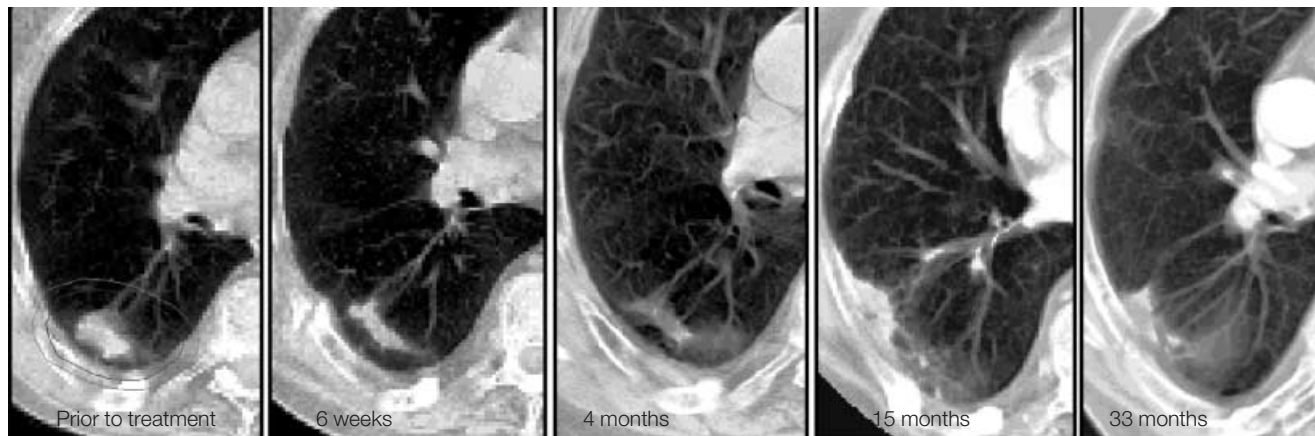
62-year-old male with a medically inoperable bronchial carcinoma (squamous cell carcinoma) in the right lower lobe. Stereotactic irradiation was performed with three fractions of 10 Gy, normalized to the PTV enclosing 65%-isodose. CTV and PTV were 91 cm³ and 174 cm³. The CT scans during follow-up show after initial shrinkage of the tumor progressive fibrosis of the irradiated area. After 15 months a CT assisted biopsy was taken to exclude local recurrence, which revealed fibrous tissue. In the further follow-up no signs of tumor progression were observed.
